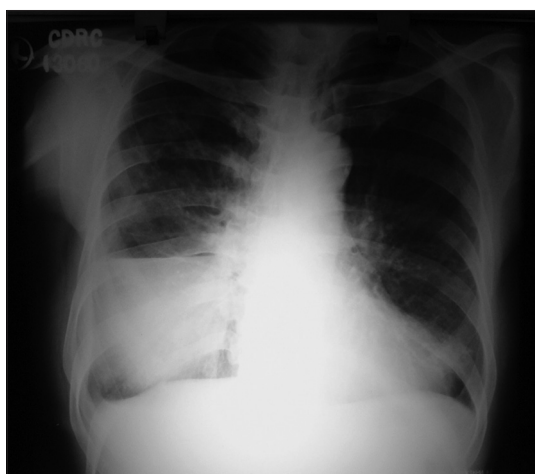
Chest X-ray (August 2012) showing air-fluid level with encysted pleural effusion on the right side
